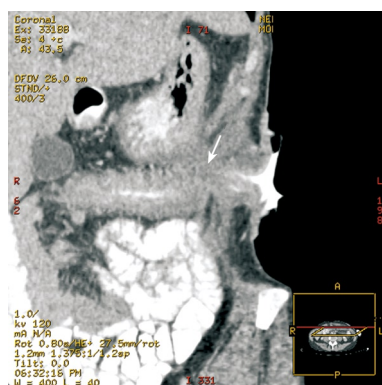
Enterogastric fistula from the corpus of the stomach to stoma on abdominal computed tomography (white arrow).
